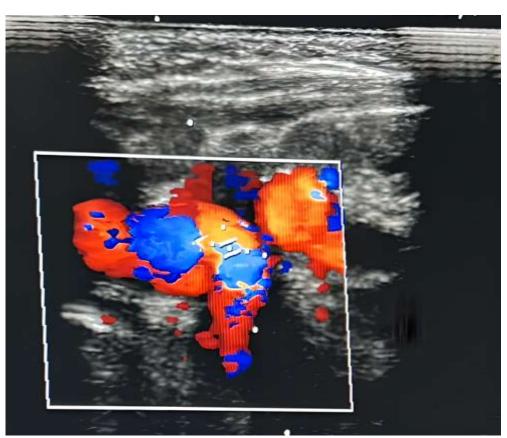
Color Doppler echocardiogram image showing direct communication between the external carotid artery and the internal jugular vein.
